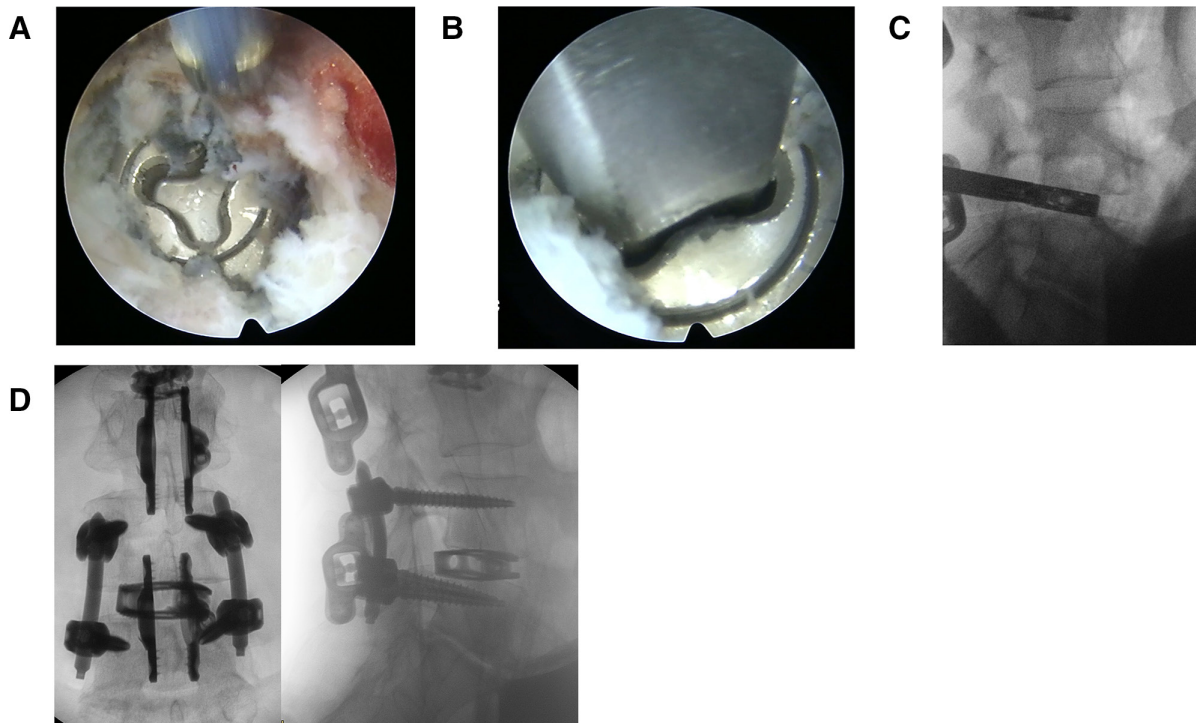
(A) An endoscopic view of a migrated titanium expandable cage. (B) An endoscopic view of the screwdriver docked into the mechanism of the expandable cage used to collapse the cage and reduce its footprint. (C) Fluoroscopic lateral intraoperative view of a forceps grasping the collapsed expandable cage. (D) Postoperative x-ray control images of the lumbar spine in anterior/posterior (left side) and lateral (right side) views with a large footprint expandable cage placed into L4-L5 and a posterior fixation.
